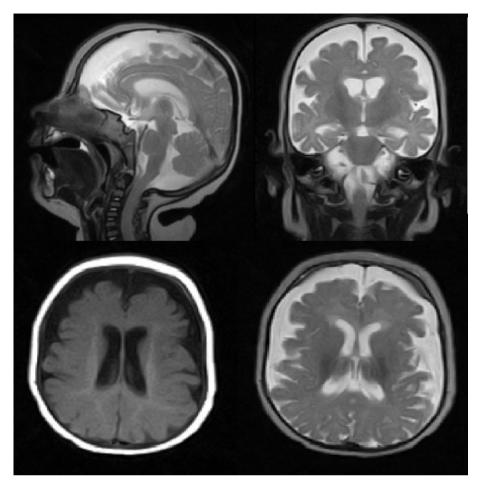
Magnetic resonance imaging of the brain of Patient. Note diffuse symmetric atrophy of cerebral cortex, atrophic ventriculomegaly, delay in white matter myelination.
